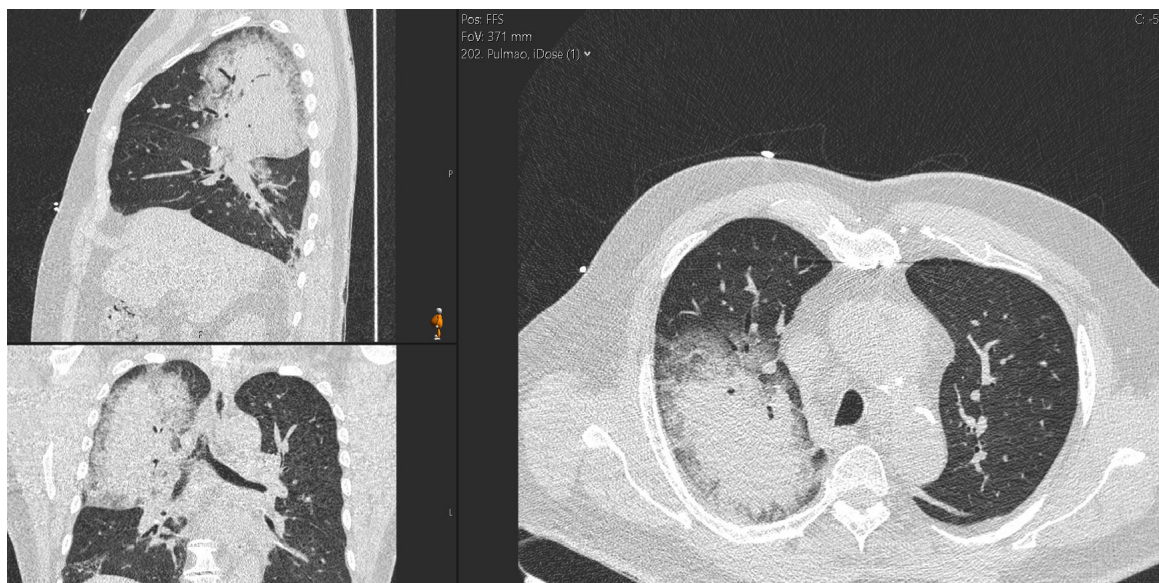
Chest CT showing extensive consolidation with air bronchogram in the upper right lobe, compatible with infectious lobar pneumonia.
